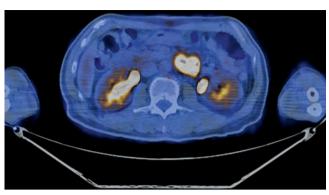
On the 3rd portion, hyperemic luminal encircling mass with easy contact bleeding. Partial obstruction noticed. The scope could not pass through this lesion. At PET-CT, strong F-18 FDG uptake (SUV=13.3) was found
